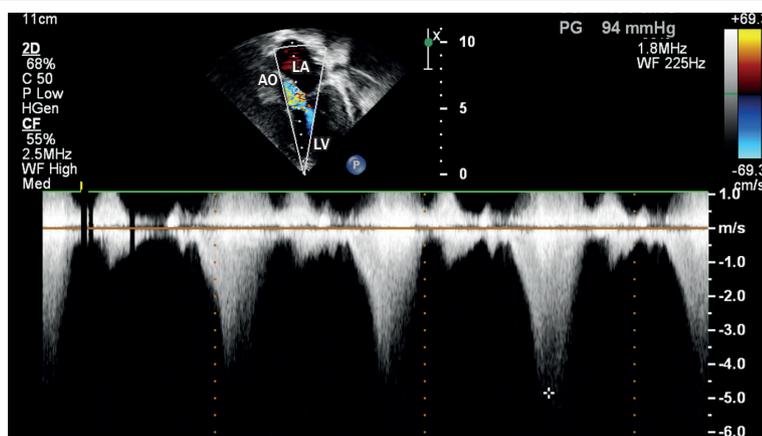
Apical five-chamber view, showing obstruction to flow in the outflow tract of the ventricle on color Doppler. Maximum gradient obtained in the ventricular outflow tract = 94 mmHg. Ao: aorta; LA: left atrium; LV: left ventricle.
